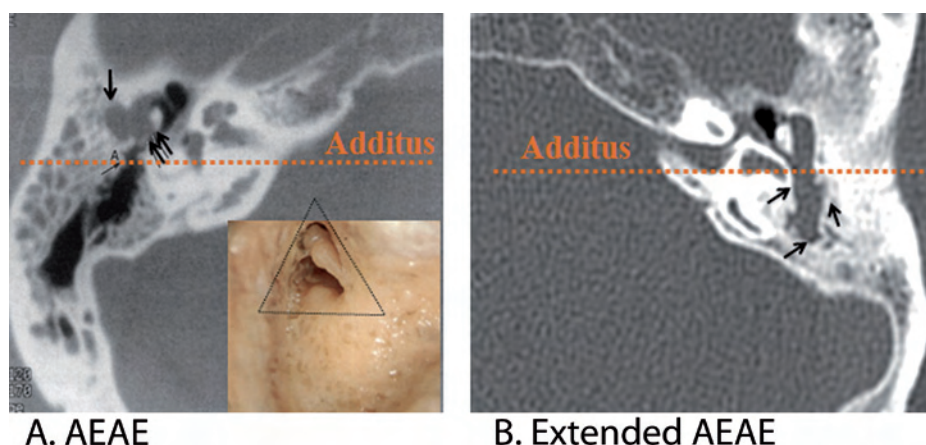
A. AE-AE indication represented in a CT scan. The cholesteatoma is located in the attic and does not invade the additus. B. Modified AE-AE represented on a CT scan. The cholesteatoma is located on the mastoid antrum.
